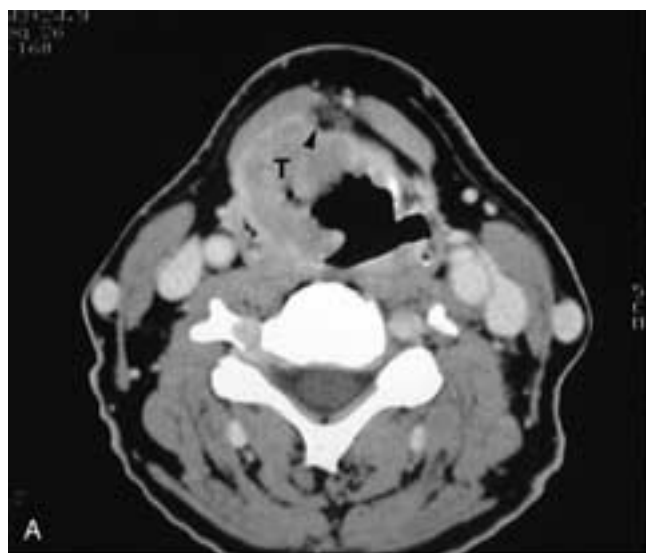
Supraglottic tumor reaching the outer edge of the true cord. Axial CT after contrast administration. A, The large bulk of the supraglottic tumor (*T*) impinges on the preepiglottic fat (*arrowhead*) and extends across the midline. B, The tumor (*T*) fills the paraglottic level of the false cord. C, The true cord level is relatively normal. A small amount of tumor (*arrow*) extends posterolaterally between the thyroid cartilage and the arytenoid. On this CT scan, it is difficult to clearly define the position of the tumor relative to the ventricle.
